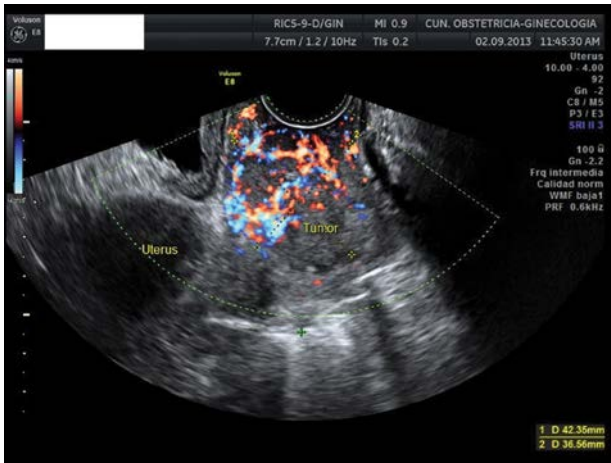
Transvaginal color Doppler ultrasonography showing the typical Doppler findings in cervical cancer. An abundant vascularization can be observed surrounding and in the tumor.
